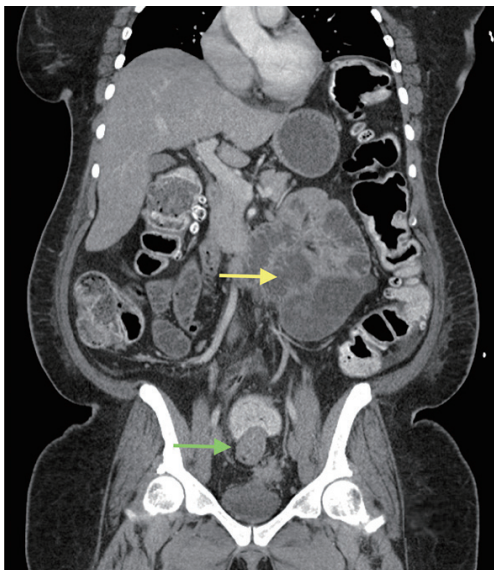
CT scan demonstrating mild dilatation throughout the colon, and dilatation of the small bowel (yellow arrow). Soft tissue nodular density (green arrow) at the rectosigmoid junction with apparent transition point.
